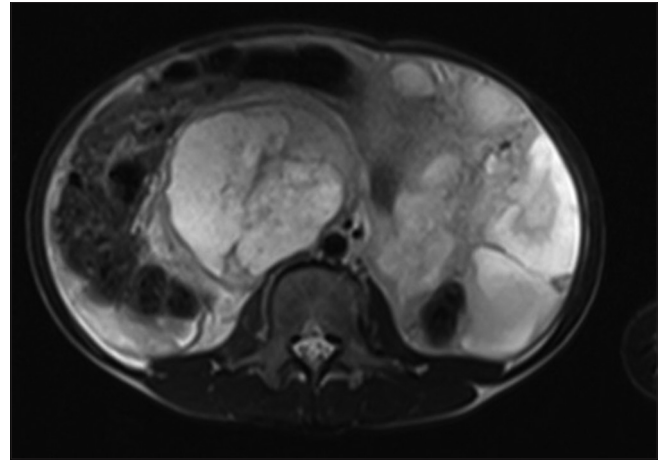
T1-weighted magnetic resonance image of abdomen showing large retroperitoneal lymph node
